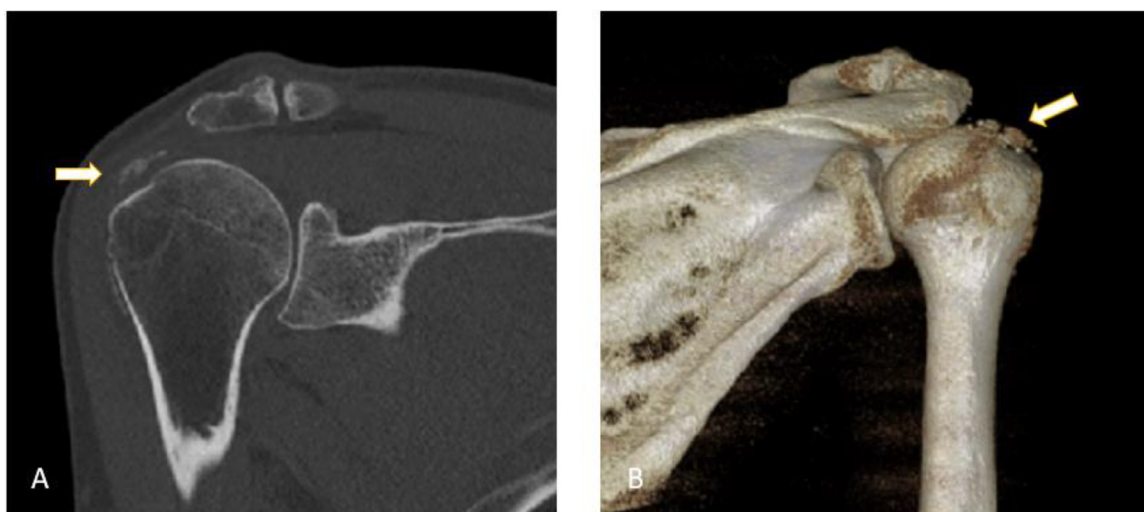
Coronal (A) plane CT image showing just little debris of the original calcification (white arrow) after UGN treatment. In (B), Volume Rendering reconstruction allows a 3-dimensional representation of data.
